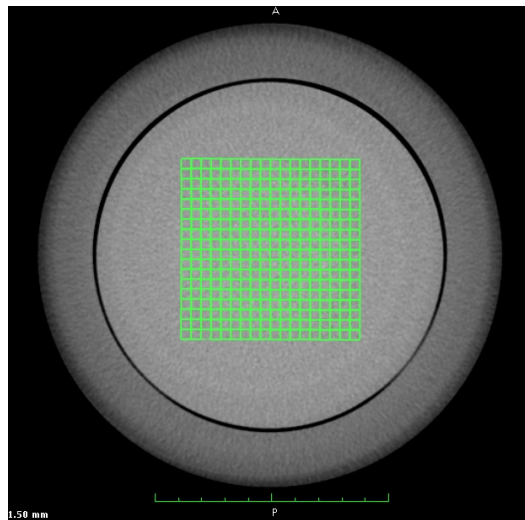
18x18 square array of ROIs for assessment of LCD from the standard deviation σ_{μ} of the mean CT numbers in each ROI
